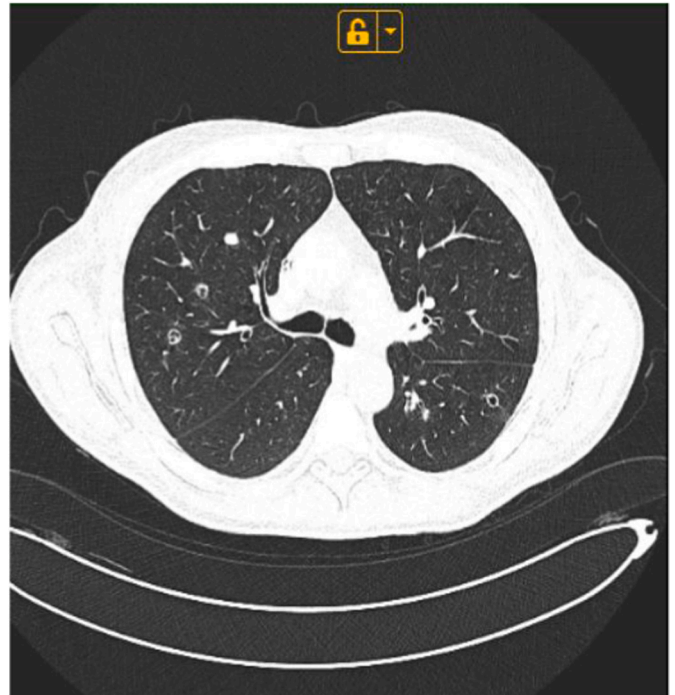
Lung CT scan performed on D+50 after second allogeneic HSCT.
